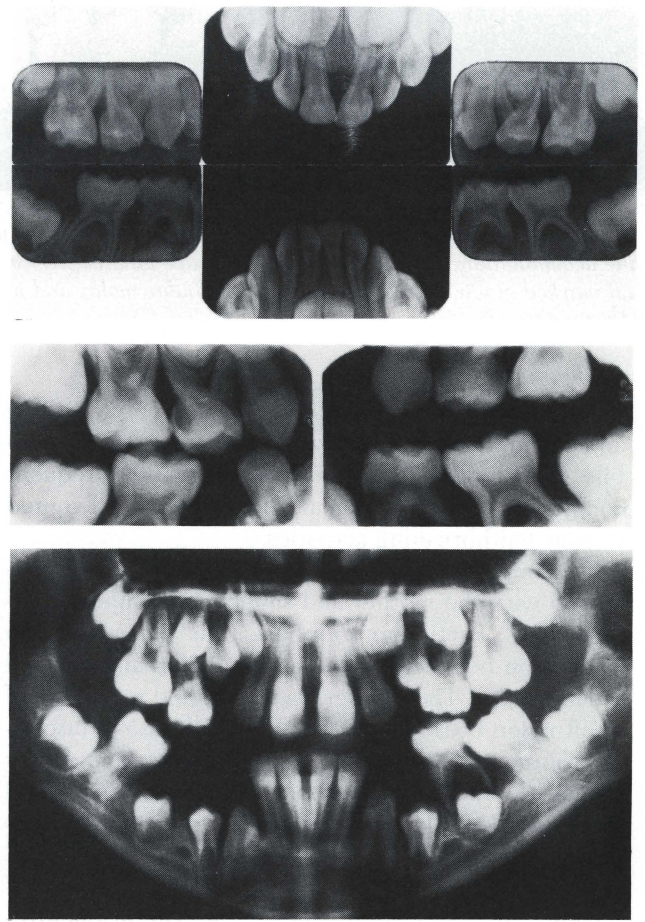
Periodic radiographic evaluations.
